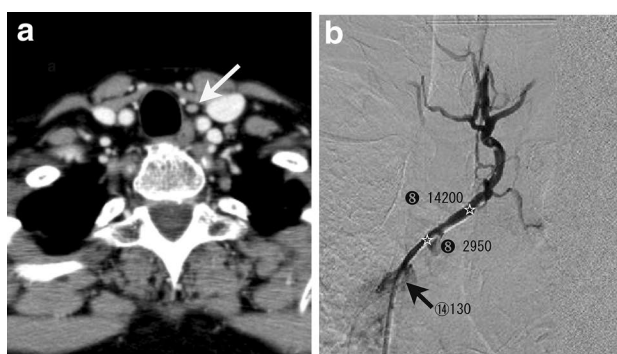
A 67-year-old female with indeterminate image findings. a A small nodule (*arrow*) is apparent inferior to the left lobe, which is indeterminate for parathyroid lesion. No suspicious lesion was detected on neither US nor ^{99m}Tc-MIBI scintigram (not shown). b, c The iPTH value is very high in the distal left inferior vein (8; 14,200 pg/ml) and then shows a steep decline (9; 2950 pg/ml). The iPTH value is not elevated in the left brachiocephalic vein (14; 130 pg/ml). A suspicious lesion is predicted in the left inferior quadrant of the left lobe. A pathological parathyroid adenoma can be seen (*gray ellipse*)
